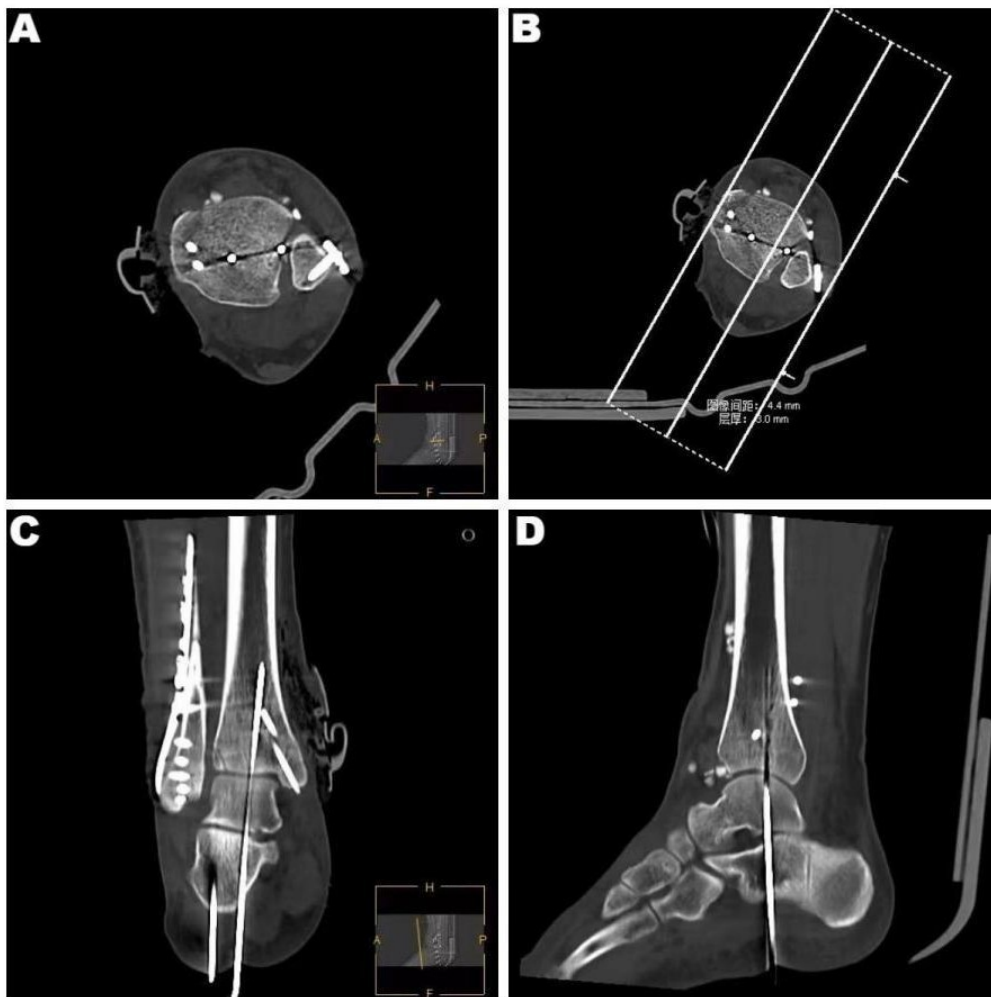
Three-dimensional CT imaging of ankle joint on the 1th day after operation
